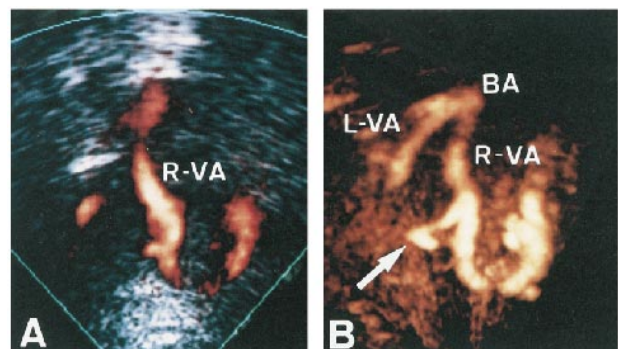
2D and 3D power-Doppler images.
